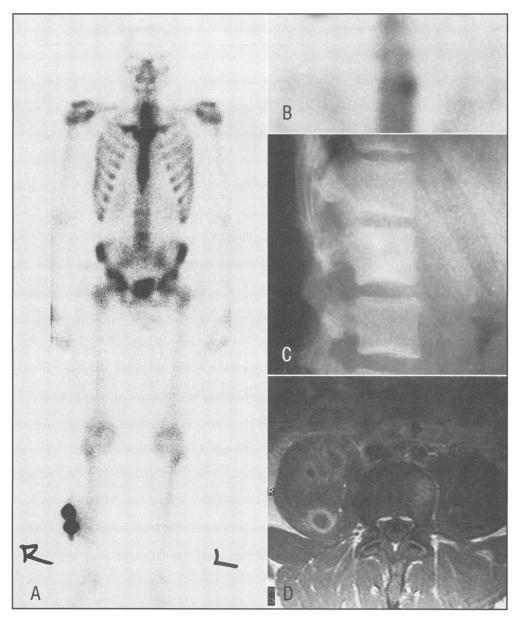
Imaging techniques are shown that were used to define the extent of disseminated coccidioidomycosis in a patient. A, A bone scan was done because of a complaint of minor lower back pain; it showed subtly abnormal uptake in the second lumbar vertebra. B, Tomographic scanning of the second lumbar vertebra produced higher resolution and demonstrated asymmetry of the abnormal uptake. C, Planar radiographs confirmed a lytic lesion to be present in that region. D, Magnetic resonance imaging of the spine confirmed the findings in the second lumbar vertebra and also showed a lytic lesion in the fourth vertebra with associated abscesses in the surrounding muscles. These images were used to follow the progress of therapy and to determine the need for surgical debridement in addition to antifungal therapy. (A, B, and D are courtesy of Maria C. Tartak, MD, and Kelly McAleese, MD.)
